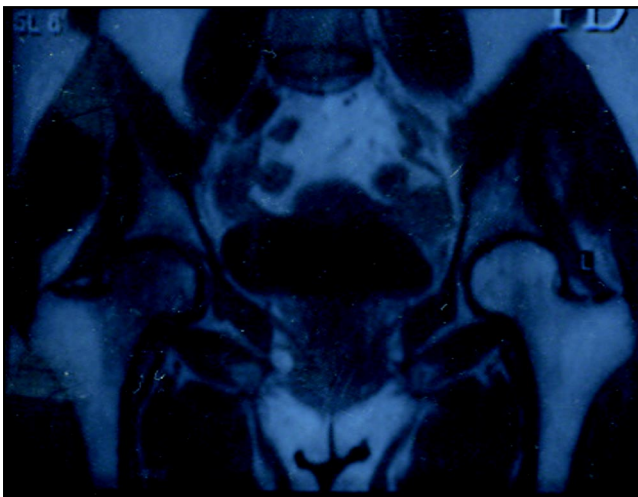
T1 weighted MRI picture showing hypo intensity in the head and neck of right femur.
